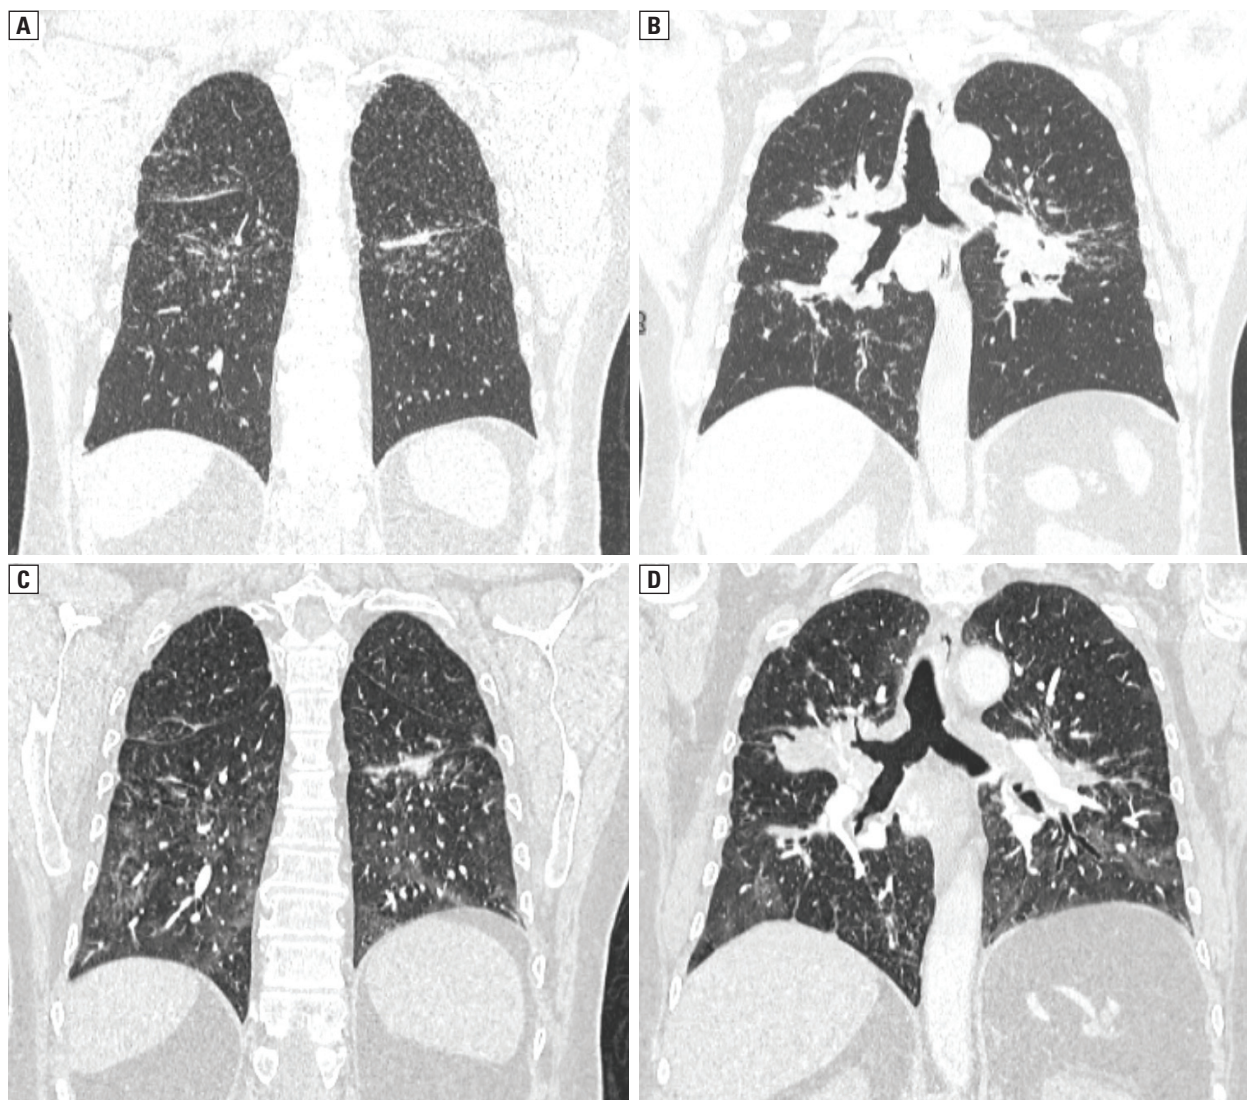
A, B. Coronal reformatted CT images before SARS-CoV-2 infection, lung window. Ill defined nodules and perihilar areas of consolidation. Bilateral hilar lymphadenopathy. C, D. Coronal reformatted CT scans during SARS-CoV-2 infection, lung window. Diffuse ground -glass opacities mainly in the middle and lower parts of lungs, superimposed on previously seen interstitial lung disease
